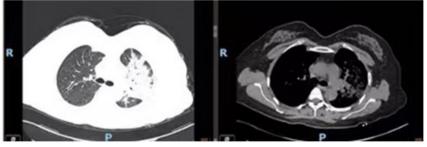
Chest computed tomography revealed consolidation of the lower left lung.
